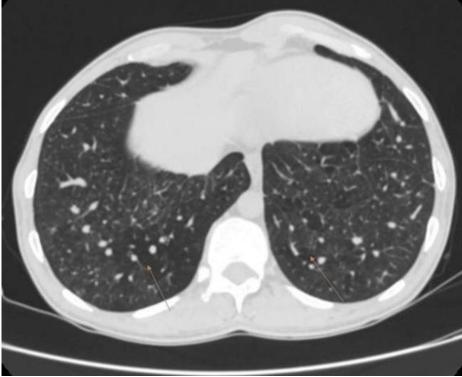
HRCT done for breathlessness.
